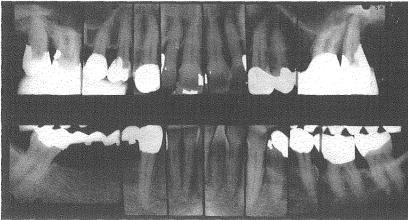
Roentgenograms taken 20 years after treatment. Note the new lamina dura and the heavy interseptal bone.
